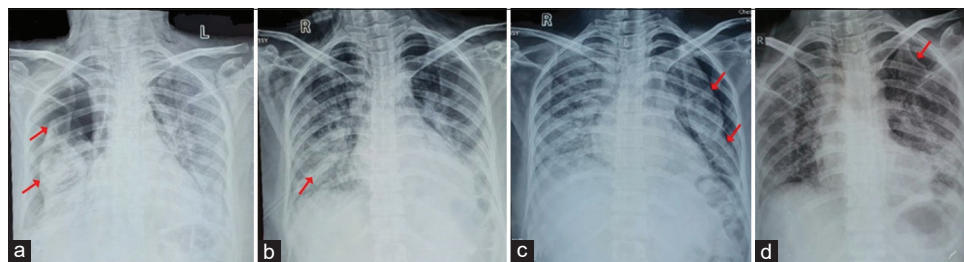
Chest X-ray Findings. (a). Chest X-ray (CXR) patients, when admitted to the hospital, bilateral infiltrates with right pneumothorax. (b). CXR 2 days after chest tube insertion, expanded right lung (c). 6 days hospitalized, CXR showed left-sided pneumothorax with multifocal patchy opacities. (d). CXR before patients discharged from hospital on 32nd day, improved of infiltrates but still minimal of left pneumothorax
